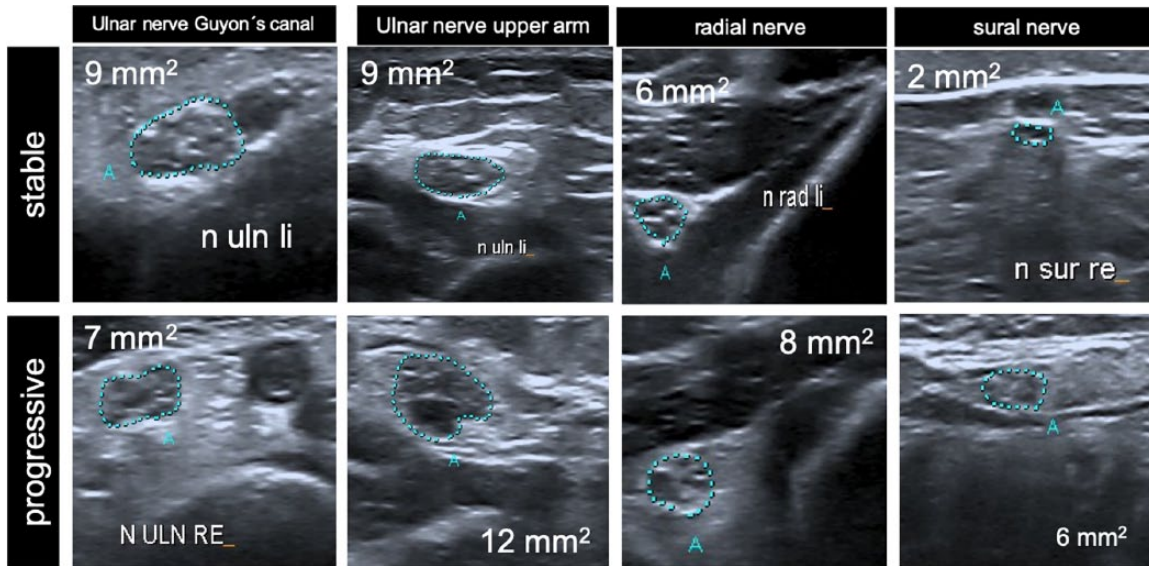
Representative ultrasound pictures of the nerves evaluated for the BUS for a stable and a progressive patient at the beginning of the study (ulnar nerve in Guyon's canal and upper arm, radial and sural nerve). The stable patient has a BUS of 1 [only ulnar nerve in Guyon's canal shows an increased CSA of 9 mm² (normal values of our laboratory <7.22 mm²) whereas the progressive patient has a BUS of 3 (increased CSA of the ulnar nerve in upper arm [<10.17 mm²], of the radial nerve [<6.2 mm²] and of the sural nerve [<3.01 mm²]).
